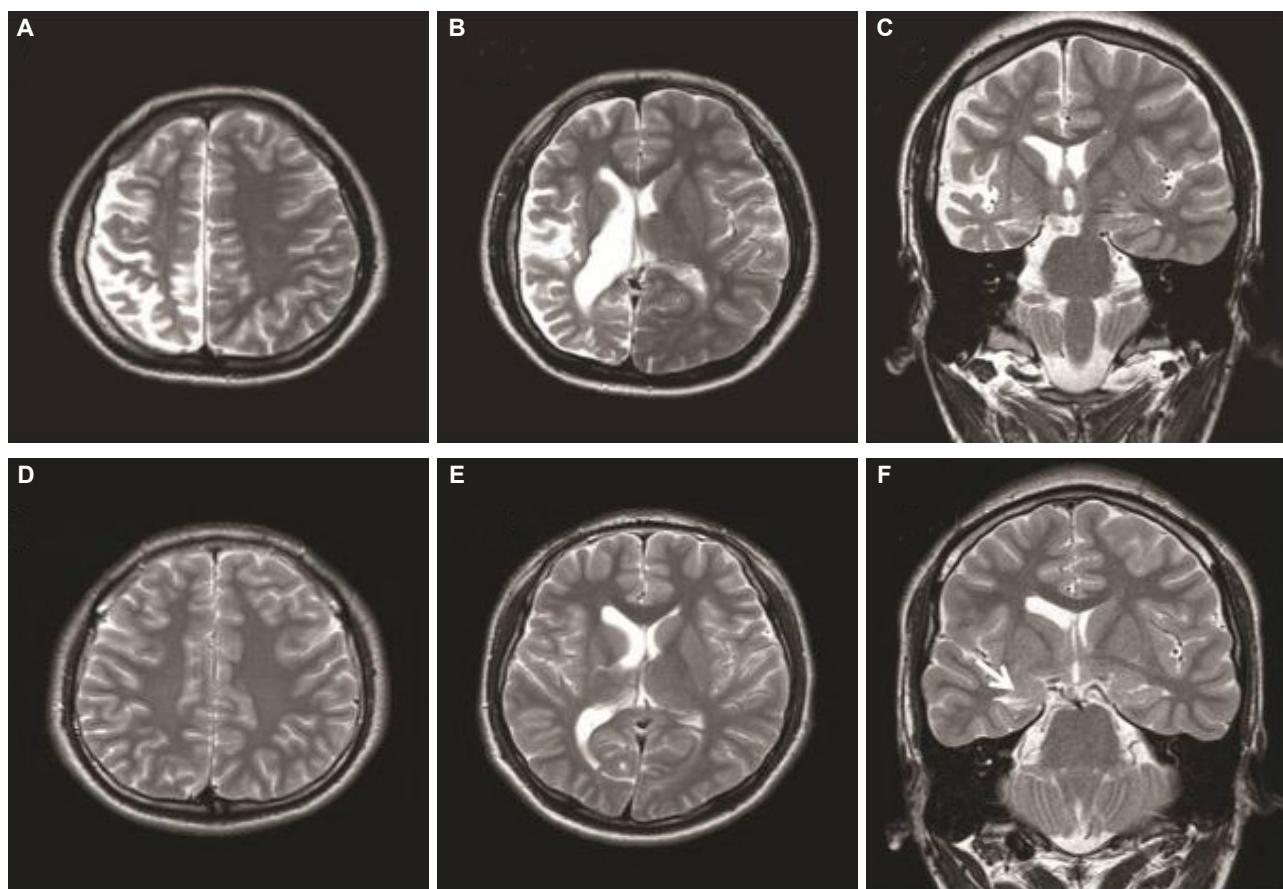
MRIs of the two epilepsy brothers. A, B, C (case 1) The T2-weighted images of the axial view and the oblique coronal view demonstrate the cortical hemiatrophy, including hippocampal sclerosis, ipsilateral skull thickening and ventricular enlargement on the right side, which is typical feature of Dyke-Davidoff-Masson syndrome. D, E, F (case 2) The images show showed the asymmetry in lateral ventricle, hippocampal atrophy in the right side (arrow). The volume of right caudate body was smaller than that of contralateral side, whereas no difference of cortical and skull thickness.
